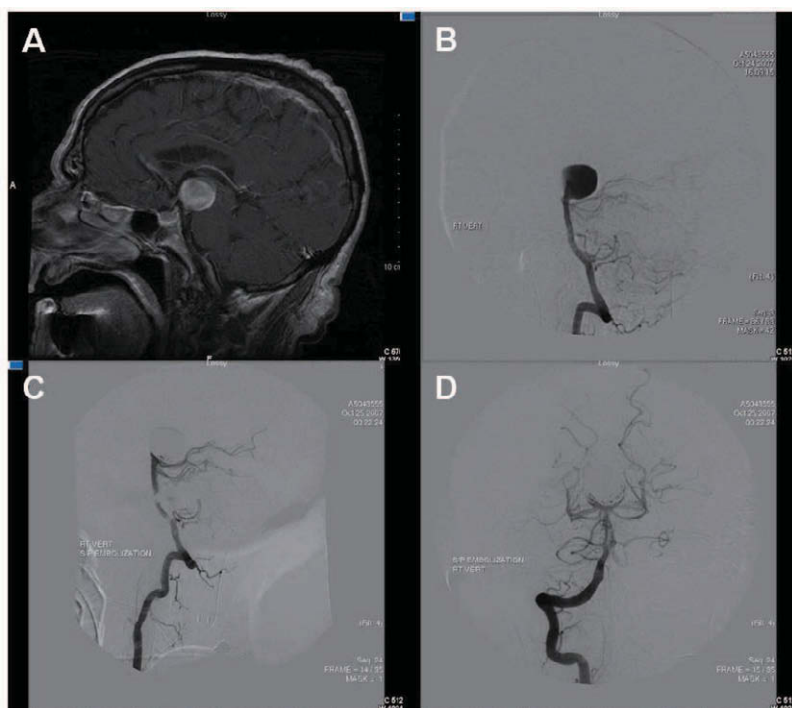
A. Sagittal T1WI MRI with contrast showing a 24 x 20 mm basilar tip aneurysm. B. Lateral view of right vertebral artery injection showing basilar tip aneurysm before coiling. C and D. Lateral and AP views of right vertebral artery angiography showing basilar tip aneurysm after successfully coiling with all major basilar artery branches presumably patent and no evidence of thrombosis compared with pre-coiling images.
